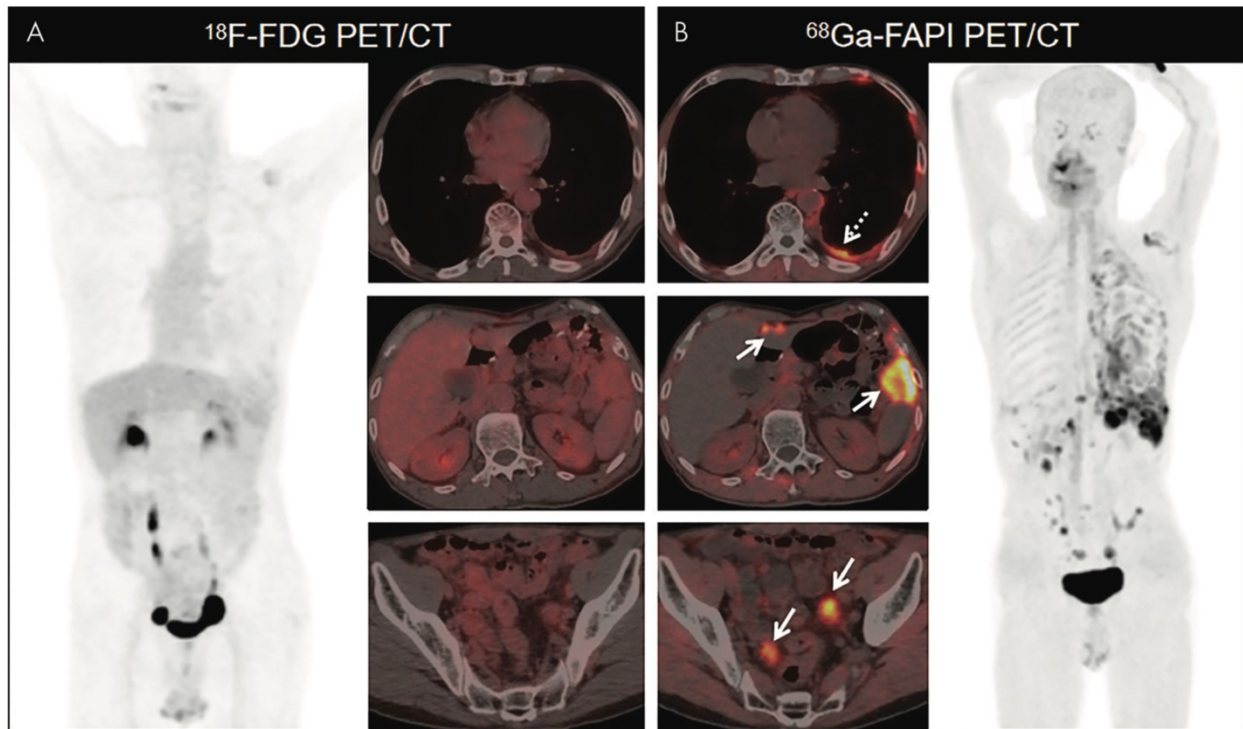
Images from a 66-year-old man who had undergone radical gastrectomy for gastric adenocarcinoma presented with abdominal pain and elevated tumor marker levels. *A*, Images from [^{18}F]FDG PET/CT show thickened pleura and multiple nodules in the peritoneum and mesentery, with low-to-moderate [^{18}F]FDG activity in these lesions (left image: anterior maximum intensity projection image from [^{18}F]FDG PET; right images: axial fused PET/CT images). *B* Images from [^{68}Ga]FAPI PET/CT show much higher tracer uptake in the thickened pleura (dashed arrow) and peritoneal nodules (solid arrows) (right image: anterior maximum intensity projection image from [^{18}F]FDG PET; left images: axial fused PET/CT images). A subsequent biopsy of the pleura and peritoneal nodules revealed metastatic gastric adenocarcinoma (poorly differentiated).
